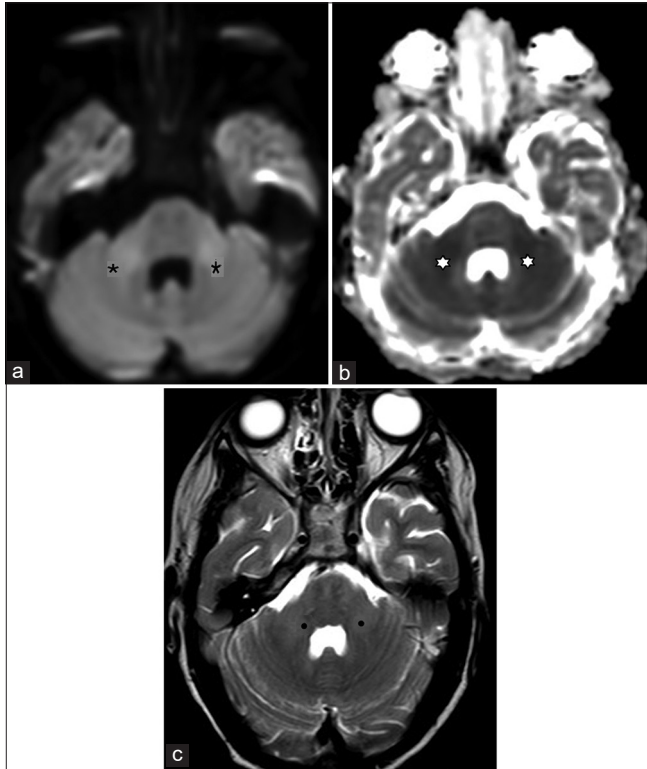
A 7-year-old boy presented with fever and imbalance while walking. First MRI brain shows (a) mild hyperintensity [asterisk] on diffusion-weighted images in bilateral middle cerebellar peduncles. (b) Low signal on ADC images [star]. (c) High signal on T2-weighted images [dots].
